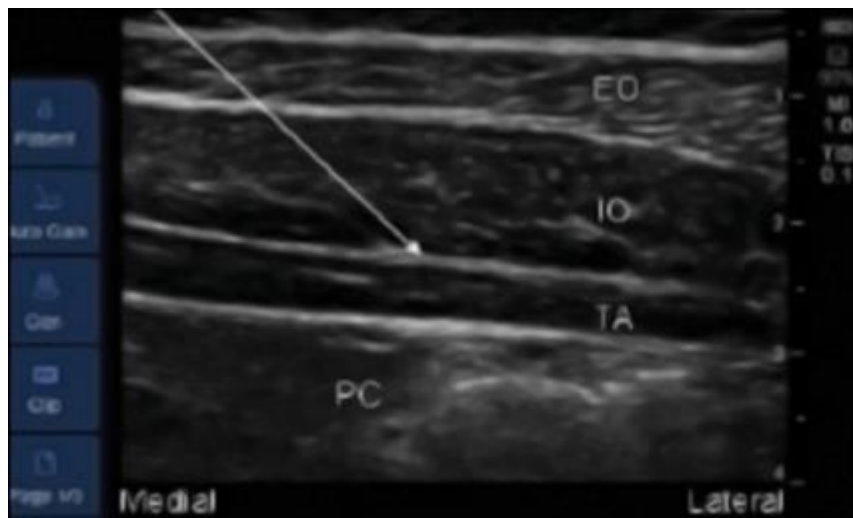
Ultrasound guided image of TAP block (20).
